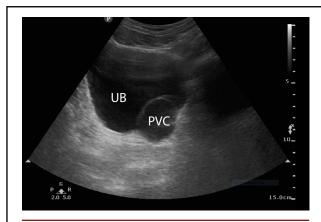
Transabdominal ultrasonogram showing a left perivesical cyst
